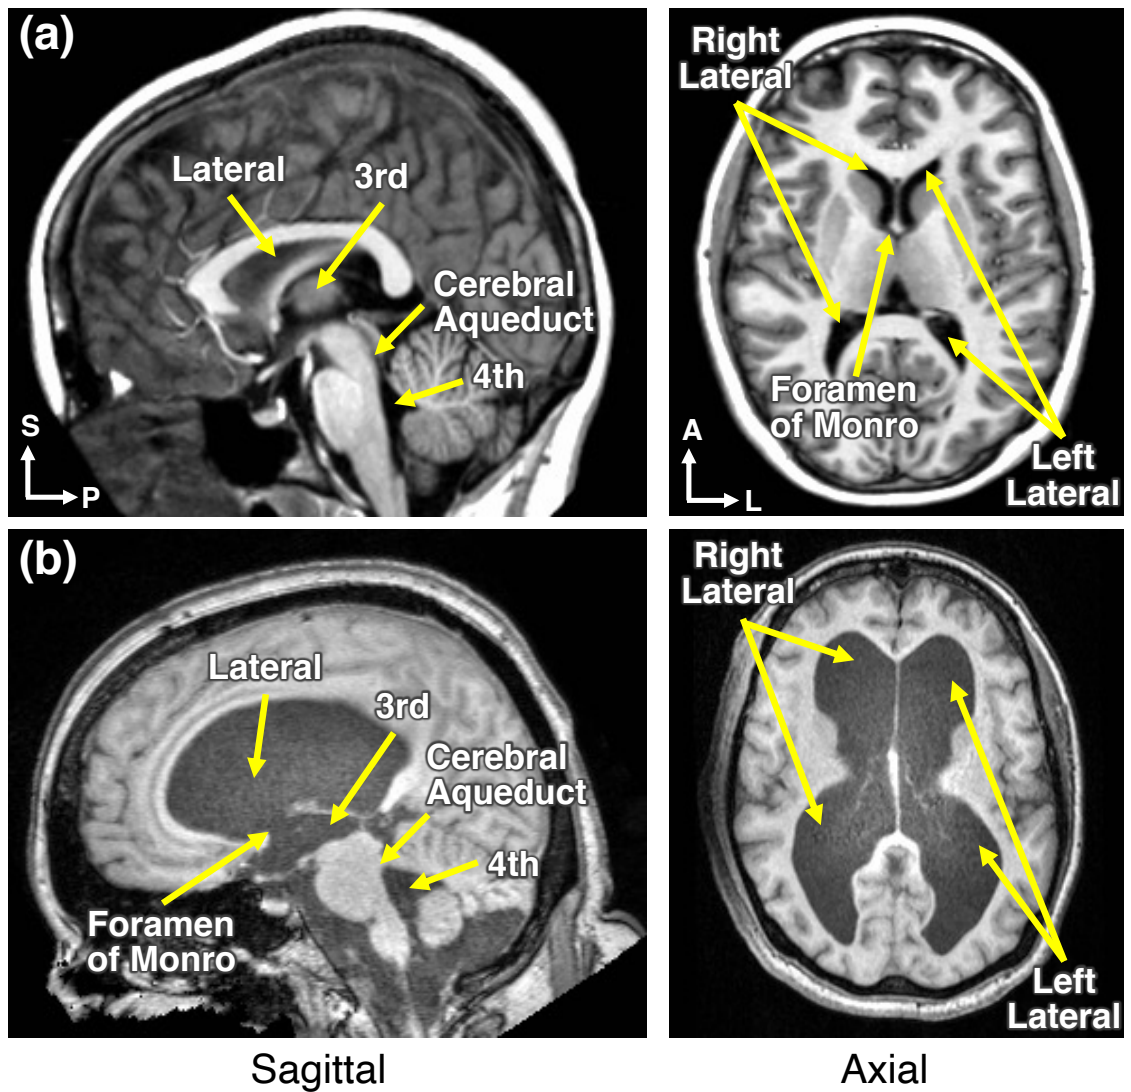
The ventricular system on an MPRAGE T1-w MRI of (a): a healthy subject and (b) an NPH subject. For each subject, the left image shows a sagittal slice and the right image shows an axial slice. S: superior; P: posterior; A: anterior; L: left.
